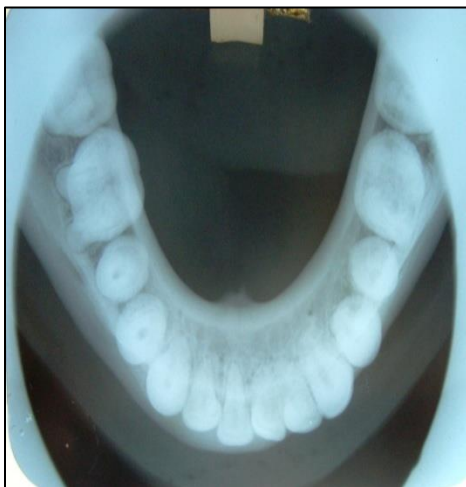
Occusal radiograph
